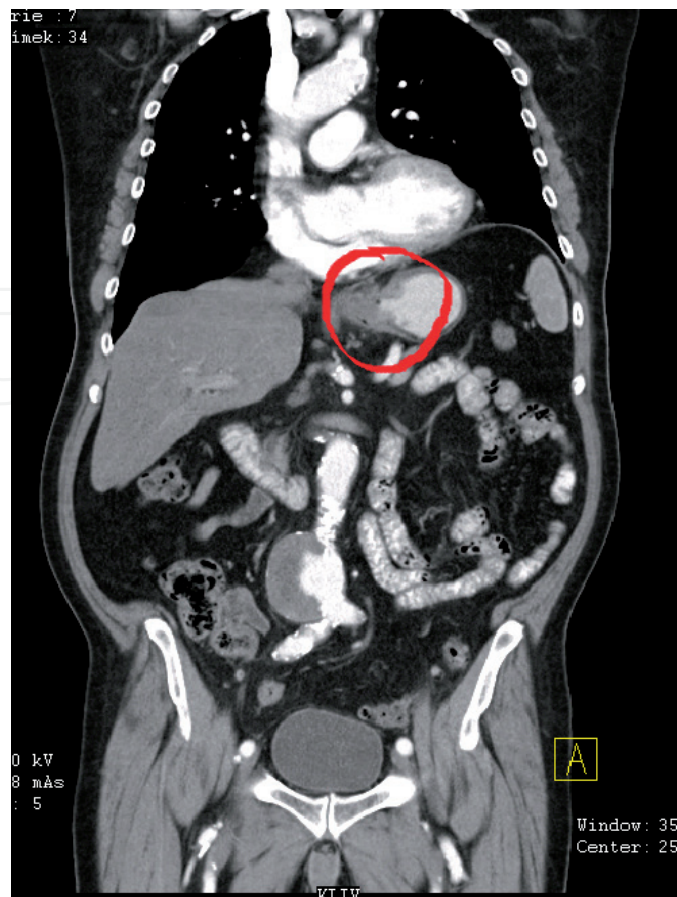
AAA and stomach tumor (CTA).
